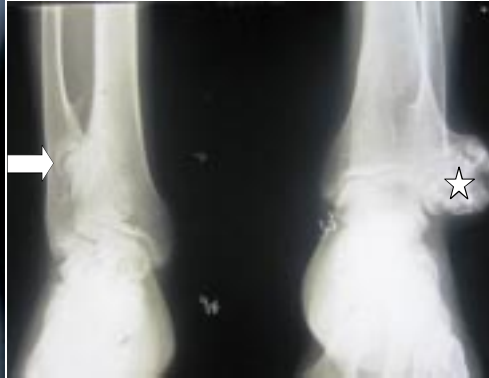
Radiograph bilateral ankle joint : Multiple pedunculated exostosis noted at with calcified hyaline cap ,Cauliflower exostoses(star).Interlocking exostosis of right sided distal tibia-fibula with pressure erosion on distal medial shaft of right fibula.(arrow)
